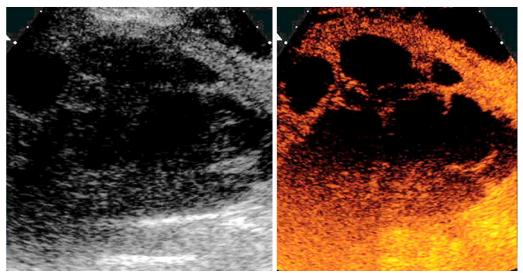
a, bOnly by the lack of CM perfusion sonography proven(symptomatic) chambered abscess formation; FS right
